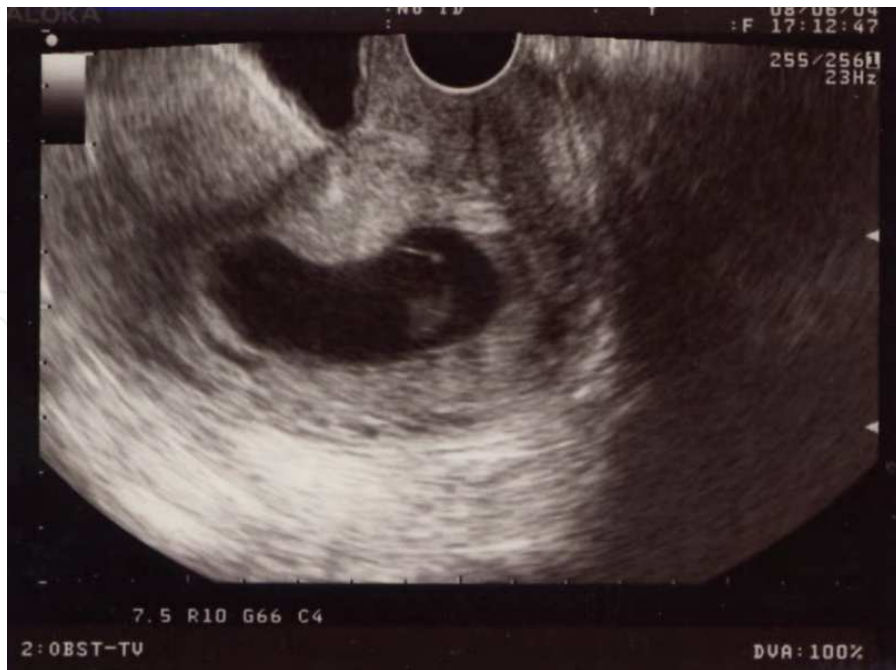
B-mode ultrasound findings at admission. The gestational sac in the swollen cervix and a heart-beating fetus are visible.
